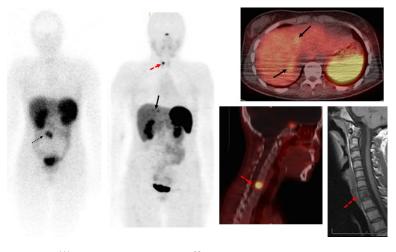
¹¹¹In-DTPA-Octreotide and ⁶⁸Ga-DOTATOC scans of a 16-year old patient with small bowel NET. The preoperative ¹¹¹In-DTPA-Octreotide whole body (left column) and SPECT/CT images (not shown) showed the primary small bowel NET in the mid abdomen (dashed black arrow) and no metastatic site. Patient had resection of the primary tumor and underwent a ⁶⁸Ga-DOTATOC PET/CT scan 2 months after the ¹¹¹In-DTPA-Octreotide scan. The ⁶⁸Ga-DOTATOC PET/CT scan (whole body maximum intensity projection images in the center and fused PET/CT in the right column) demonstrates previously unknown metastases in the liver (solid black arrows) and at C7 vertebra (dashed red arrows). Subsequent MRI confirmed the lesions; low signal C7 lesion on T1 weighted MRI is shown (dashed red arrow).
